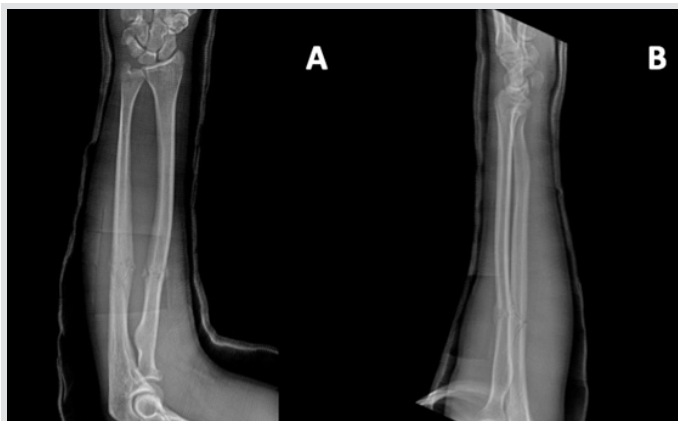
AP (a) and lateral (b) X-rays demonstrate the same fractures with interval callus formation without significant change in fracture angulation or displacement 1 month after injury. Note the window cut out of the cast at the level of the fracture to allow for ultrasound stimulator use.
